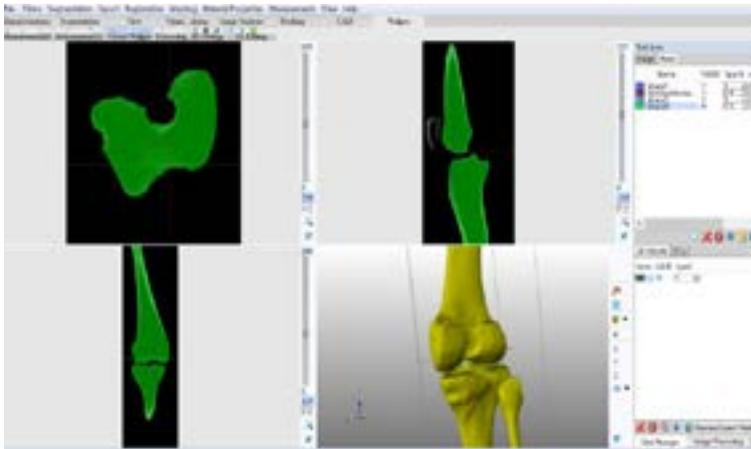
Patient CT Scan data model in ImageSim Software
